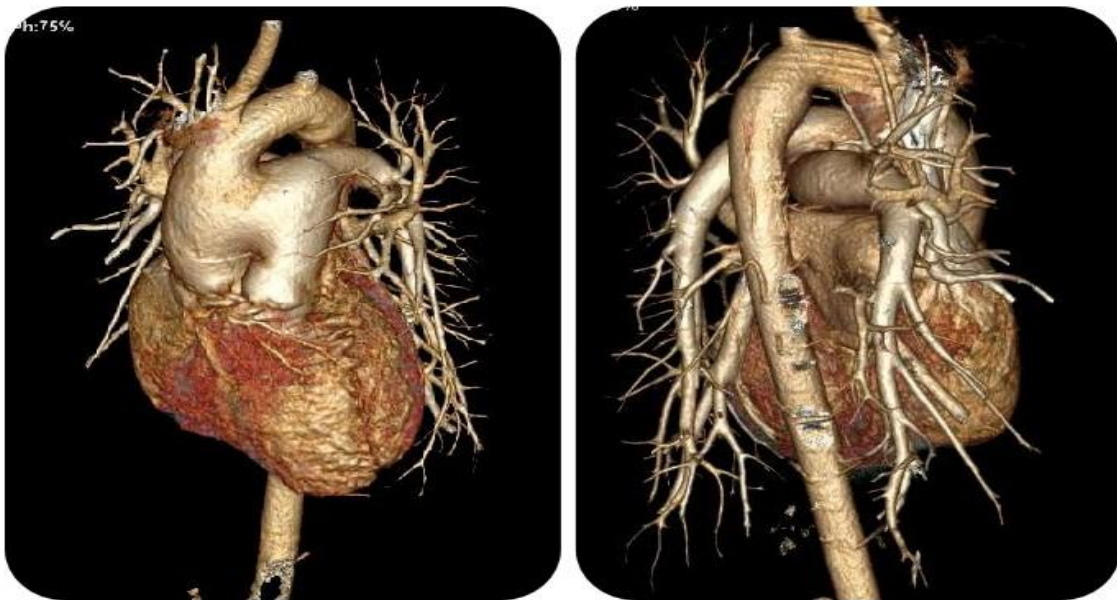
Volume rendered CT images clearly depicting a Aortopulmonary window (Type I defect)
